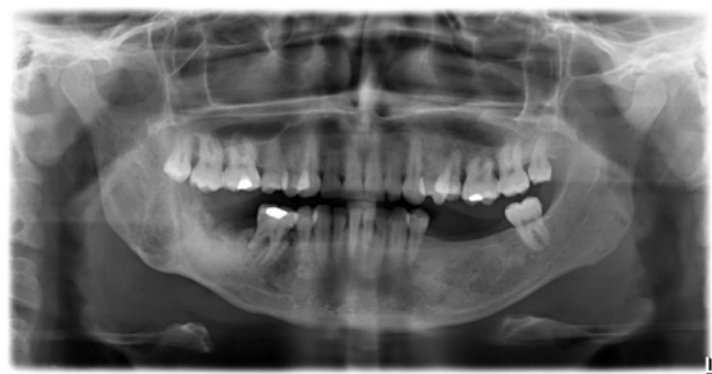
Control X-ray (orthopantomogram) four months after parathyroidectomy. There are signs of new bone formation and almost complete resolution of cystic tumefaction on both sides of the mandible.
